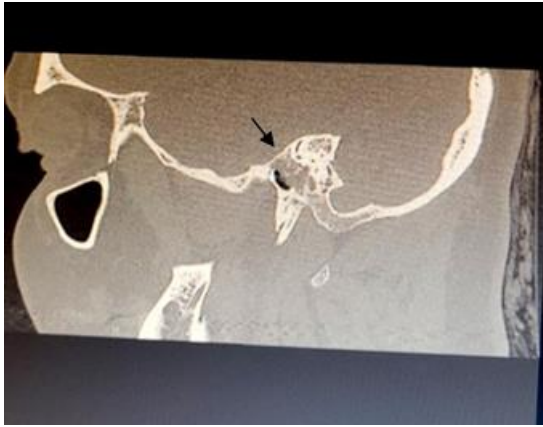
(b) High resolution computed tomography image showing soft tissue density in the right middle ear - sagittal
